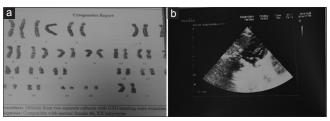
(a) Chromosomal study on amniotic fluid. (b) Echocardiography
